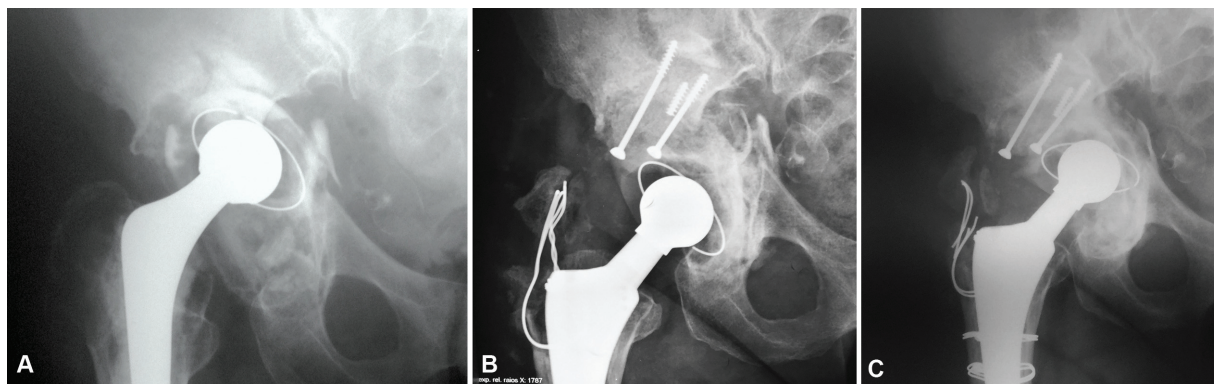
Radiographs of a 63-year-old female patient who had her right hip operated. A) preoperative radiography showing cemented total hip arthroplasty with pelvic discontinuity; Paprosky 3B, measuring 80 mm; B) immediate postoperative radiography presenting acetabular reconstruction with structural graft and cemented acetabular component; C) postoperative radiography at 3 years and 1 month after acetabular reconstruction with signs of loosening.
